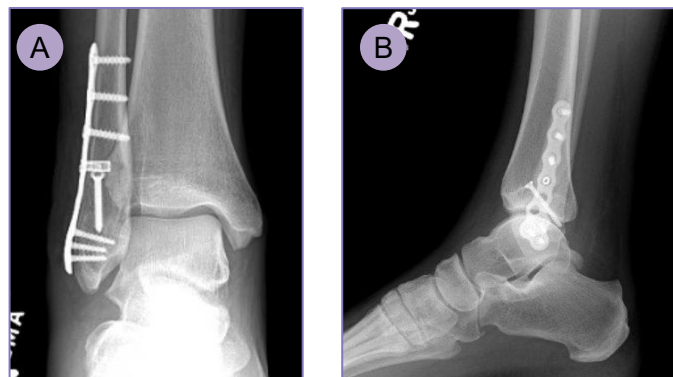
6-month post-op X-rays with the Gorilla Anatomic Fibular Plate and R3FLEX: (A) A/P (B) Lateral.
